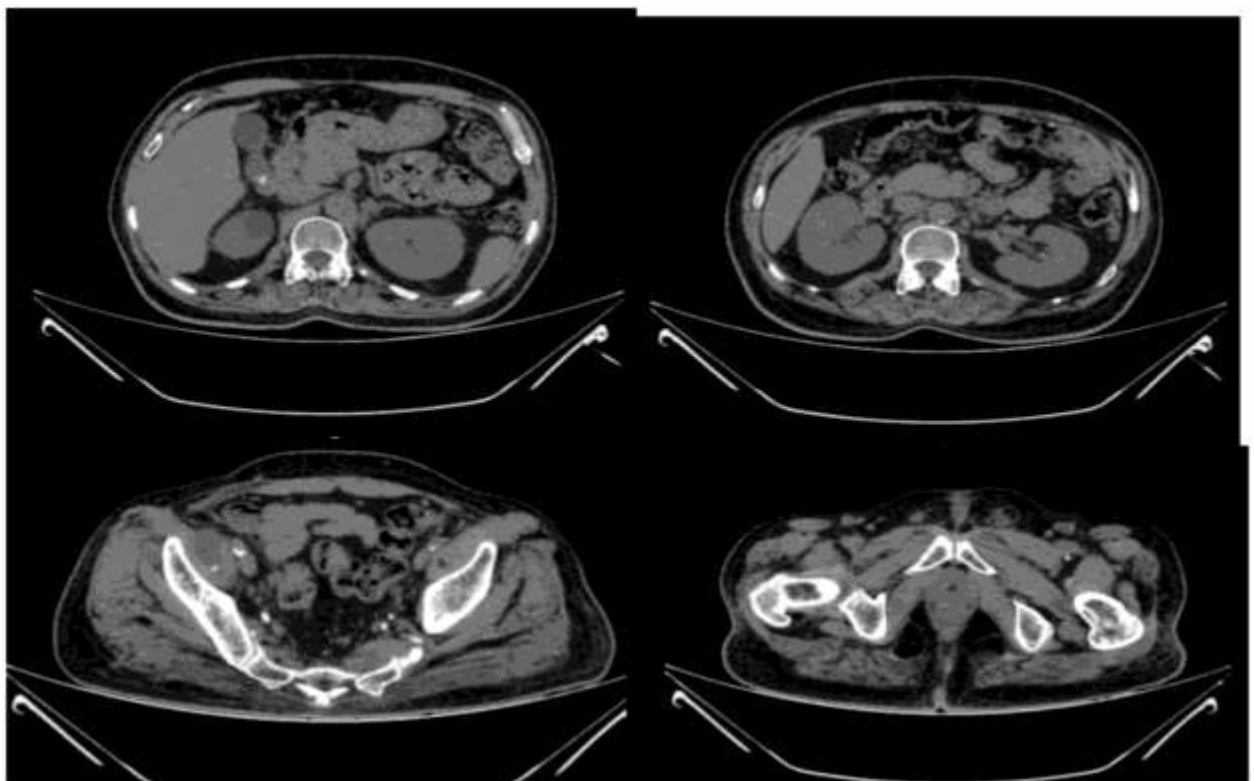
CT abdomen findings
